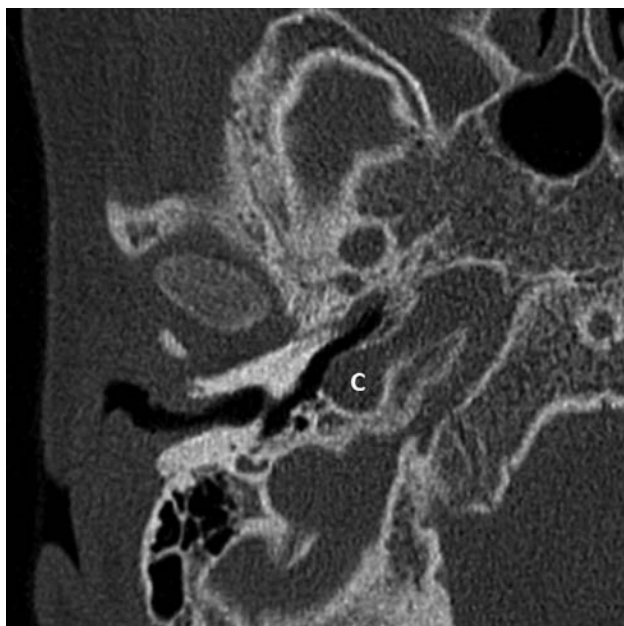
Axial CT image of the right mastoid bone showing a carotid canal dehiscence (C).
